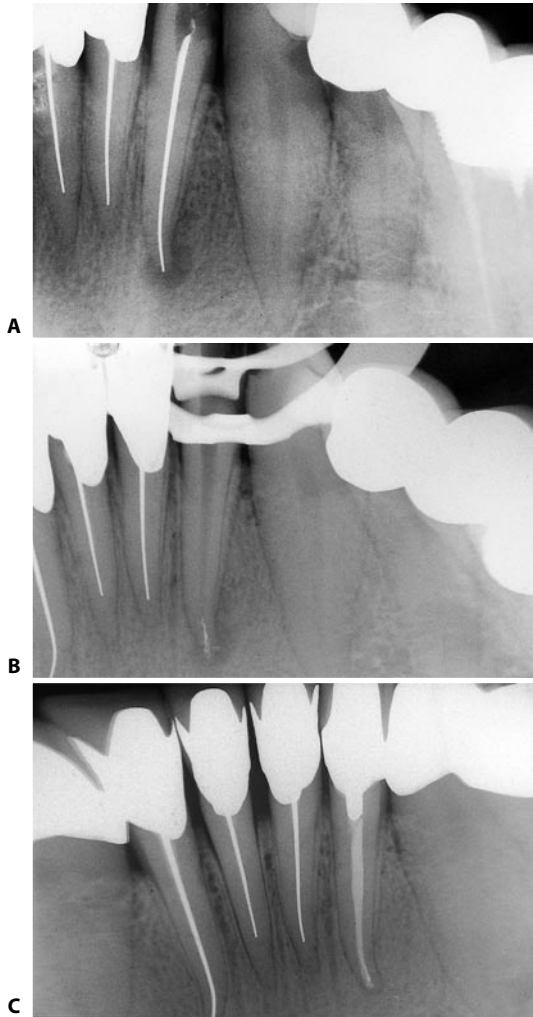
A. Preoperative radiograph of a lower left lateral incisor, which had previously been treated with a silver cone. It requires retreatment because of a symptomatic lesion. B. The silver cone has been removed with an ultrasonic endodontic handpiece. Note the presence of corrosion products of the silver cone, which “paint” the canal walls, fortunately without blocking it. C. Radiograph three years following retreatment.
